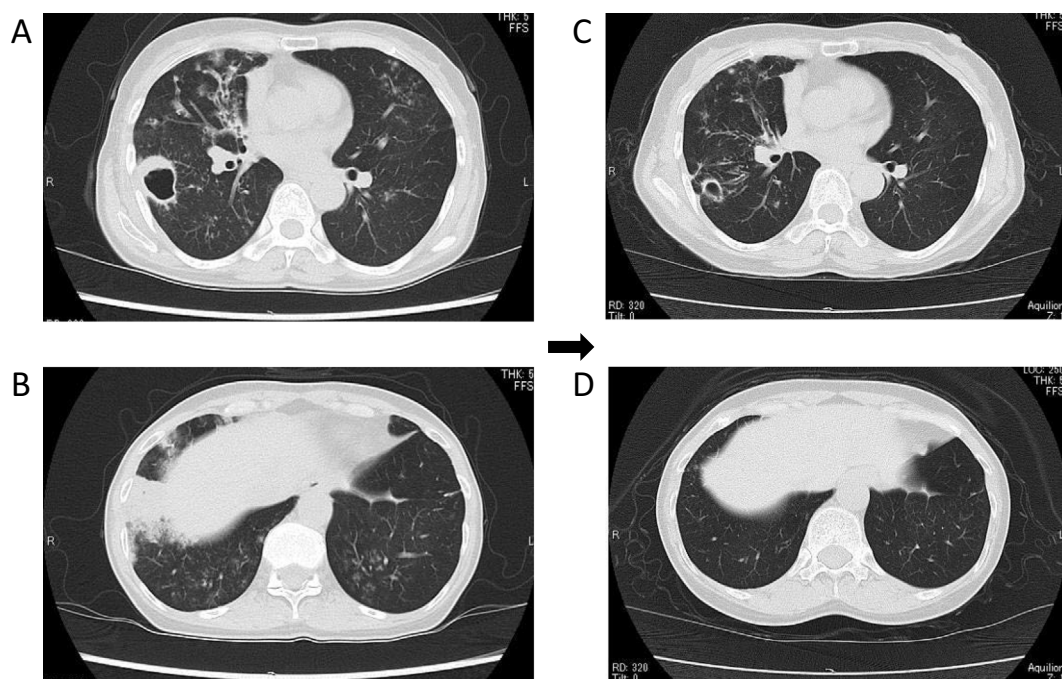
Chest CT on admission revealed small nodular shadows with bronchiectatic changes in the right middle and lower lobes and left lingula lobes and a cavity lesion in the right S⁶ segment (A) and an infiltration shadow in the right lower lobe (B). Chest CT one year after the initiation of treatment showed an improvement of small nodular shadows and infiltration shadows containing the cavity lesion, except for bronchiectatic changes (C, D).
